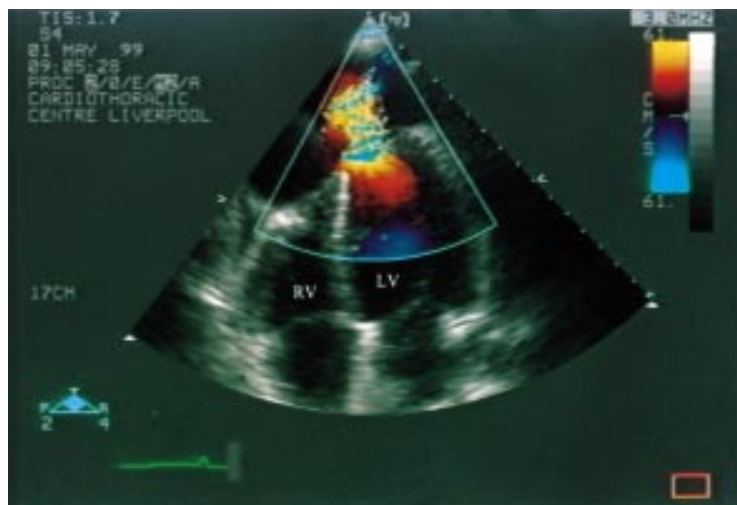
Apical four chamber view with colour flow Doppler, showing the point of cardiac rupture and false aneurysm. LV, left ventricle; RV, right ventricle.
